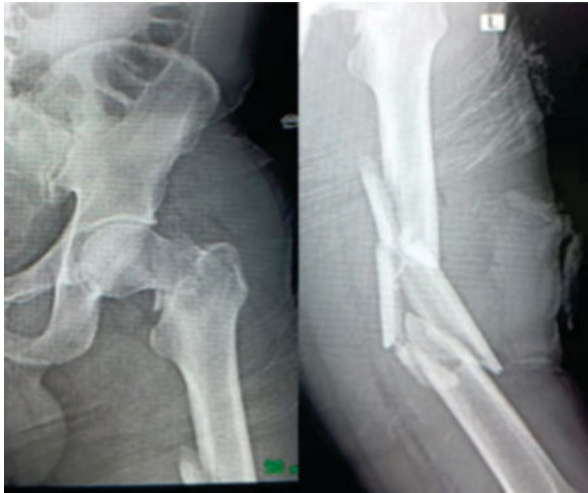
pre-operative Xrays
